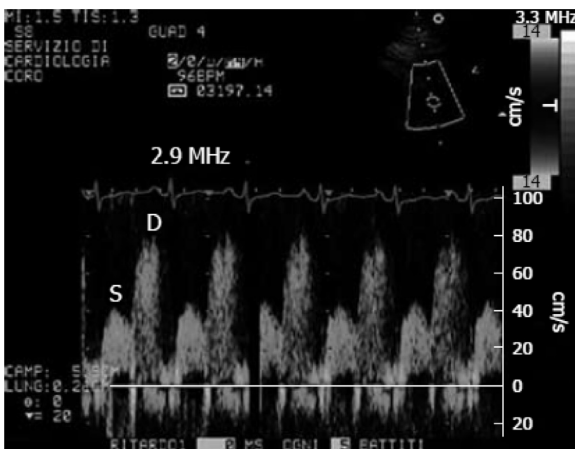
Example of coronary flow Doppler signal during dipyridamole-induced hyperaemia. D, diastolic flow; S, systolic flow.
